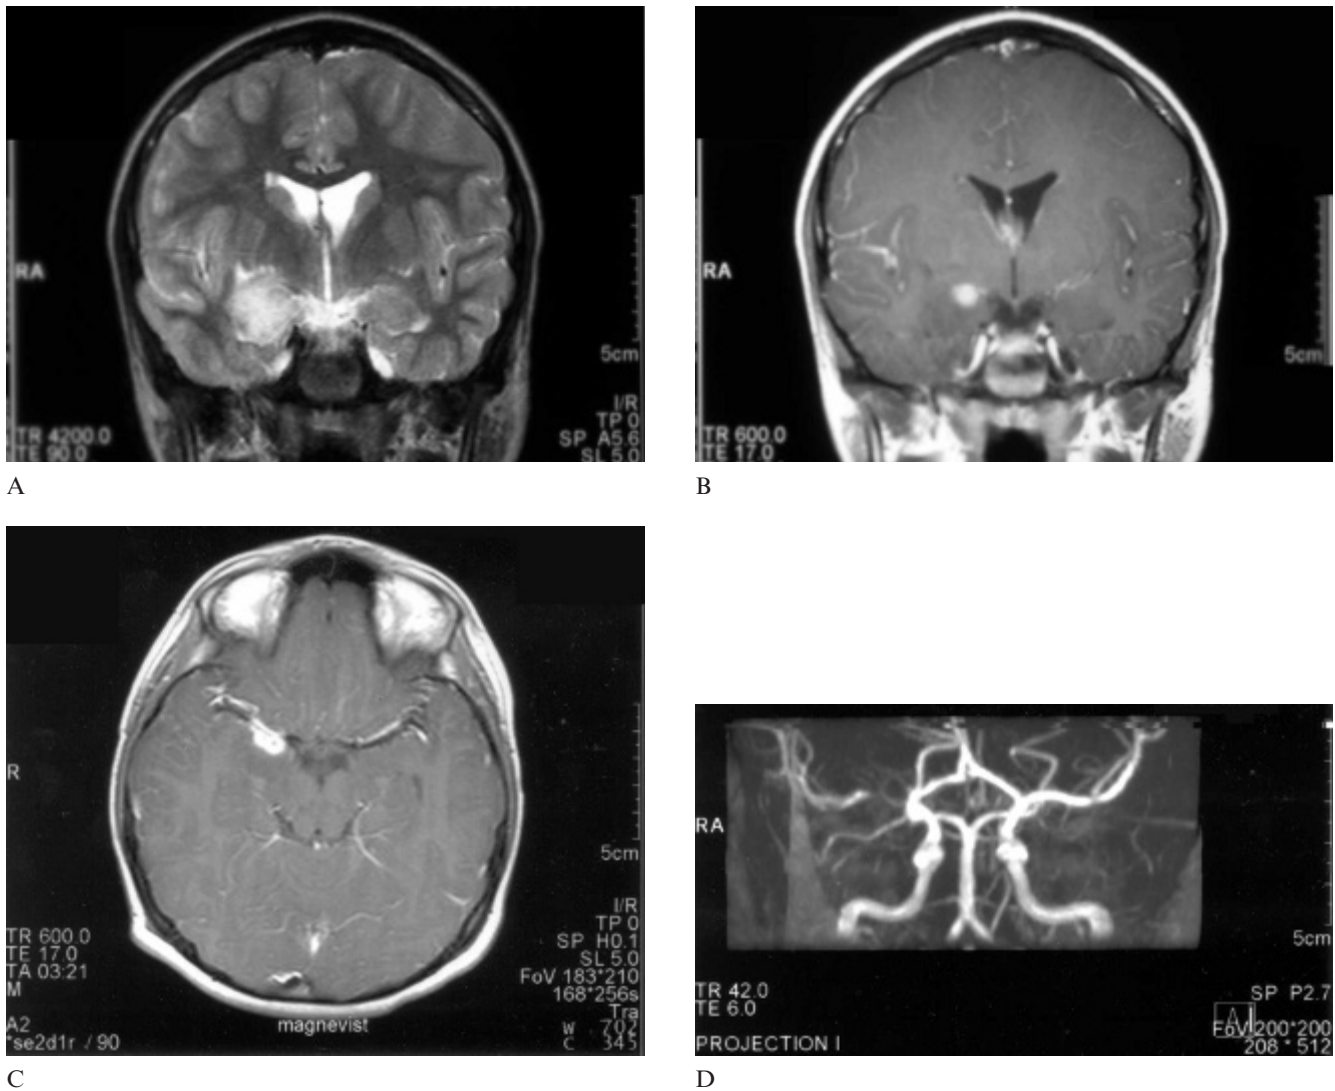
Brain magnetic resonance imaging 8 days after the initial presentation reveals T₂-weighted hyperintensity in the anteromedial temporal lobe and inferior aspects of the putamen and globus pallidus on a coronal T₂-weighted image (A). A smaller focus of gadolinium enhancement in the region of the M1 segment of the right middle cerebral artery was noted on both coronal (B) and axial (C) T₁-weighted images following intravenous gadolinium administration. Magnetic resonance angiography reveals focal stenosis at the M1 segment of the right middle cerebral artery (D).
